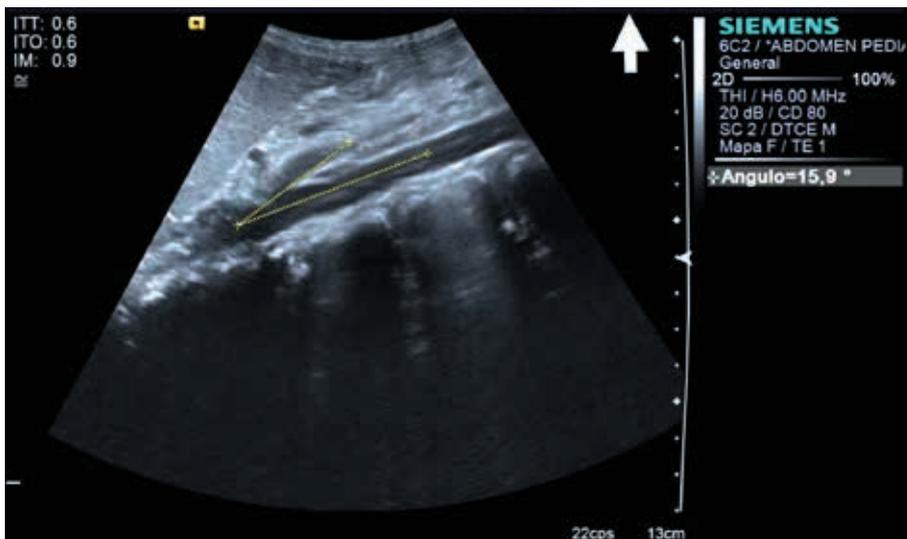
Abdominal ultrasound image showing the origin of the superior mesenteric artery from the aorta, with a 15.9° angle. The left renal vein can be observed between both structures.
